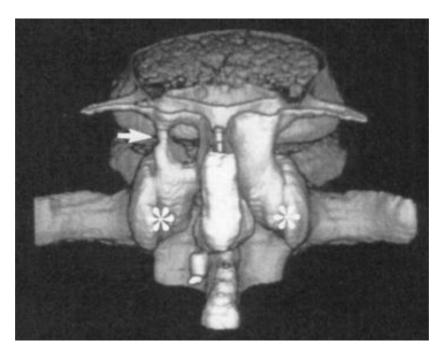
Pars interarticularis fenestration. Postoperative three-dimensional CT scan. Delineation of the pars interarticularis ovoid fenestration. Arrows point to the isthmic notch and the asterisks mark the zygapophyseal joints. (from Di Lorenzo et al 1998)
